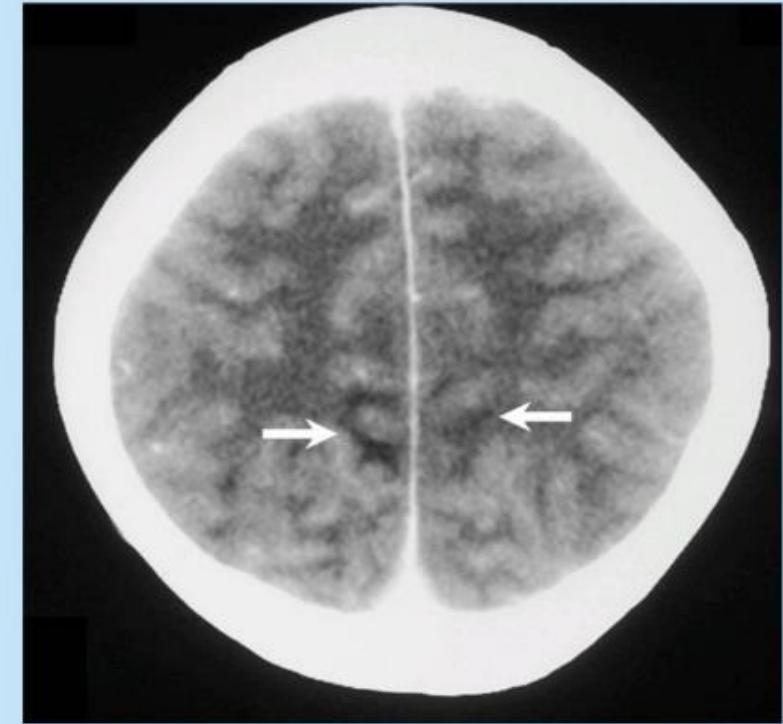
Axial post-contrast CT scan of the brain shows bilateral parafalcine posterior parietal white matter low densities (arrows) without associated enhancement.
